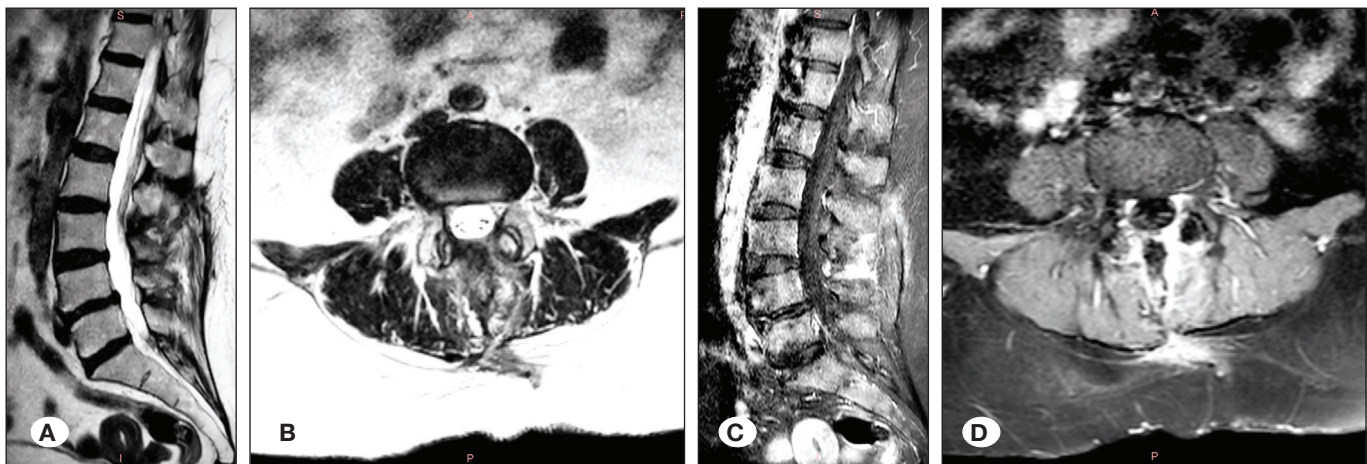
Postoperative T2W sagittal and axial (A, B), and gadolinium-enhanced T1W MR images (C, D) show that the contrast-enhancing lesion disappeared and the neural tissues were decompressed.
